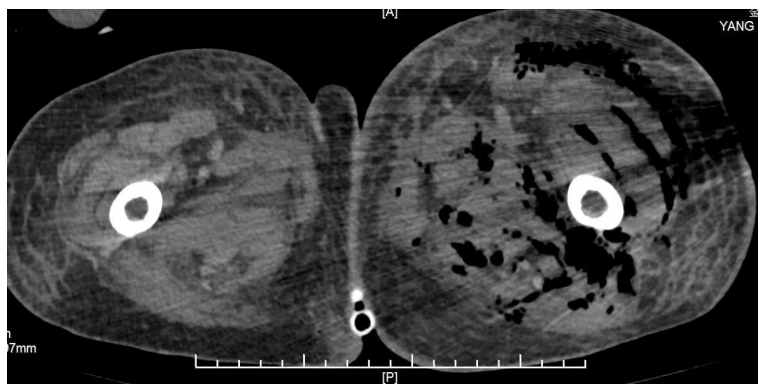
CT on February 18: Significant edema and pneumatization of soft tissues around the left hip, buttock, and thigh, progressing from the previous.
